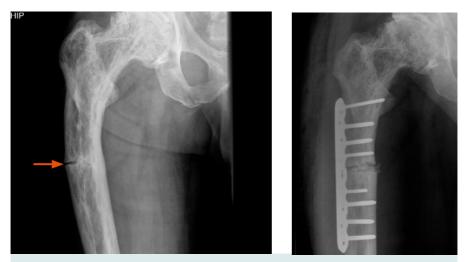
The x-ray on the left shows a fracture (indicated by the arrow) of the femur and on the right its repair
